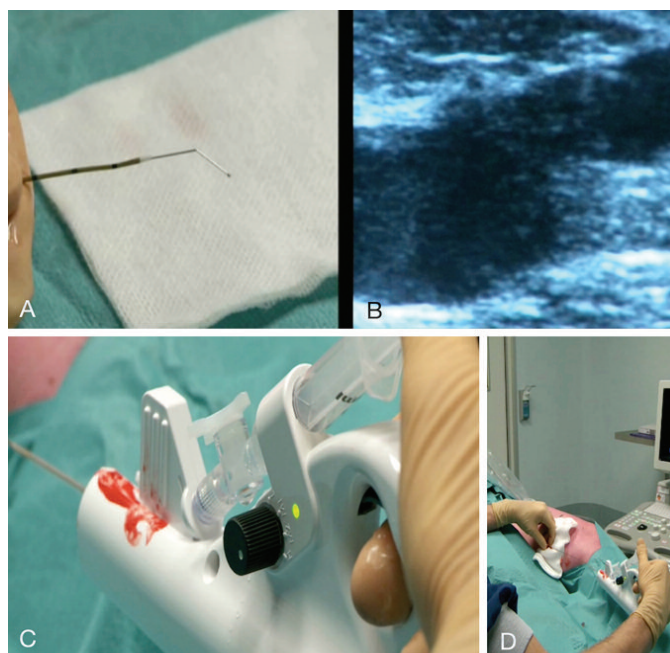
The unsheathed bent tip (A) is positioned approximately 2cm distal to the saphenofemoral junction (SFJ), or just below the orifice of the epigastric vein, as verified by ultrasound (B). Then the wire is activated by the motorized handle (C), after which the catheter with rotating tip is slowly withdrawn at a speed of approximately seven seconds per centimeter, while the sclerosant is continuously injected (D).
